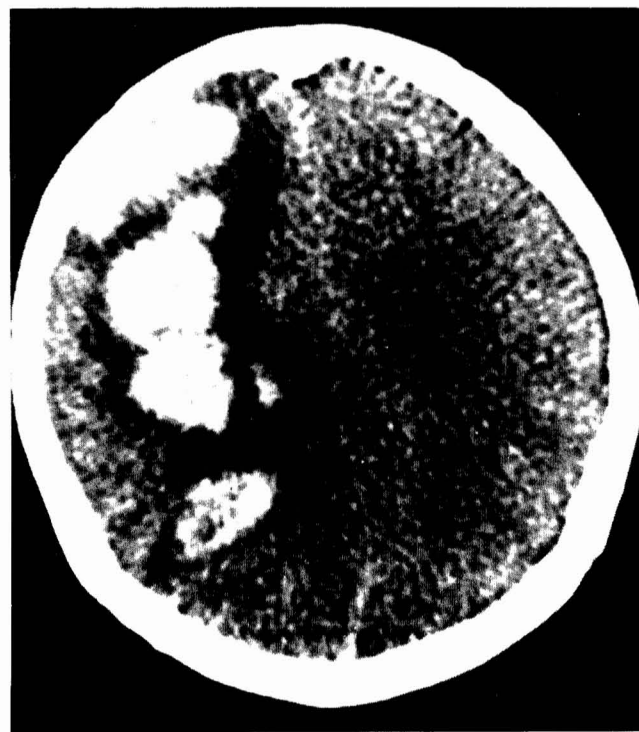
CT scan 6 days after carotid endarterectomy shows a large, irregularly shaped hemorrhage extending through the left frontotemporal and parietal lobes.
